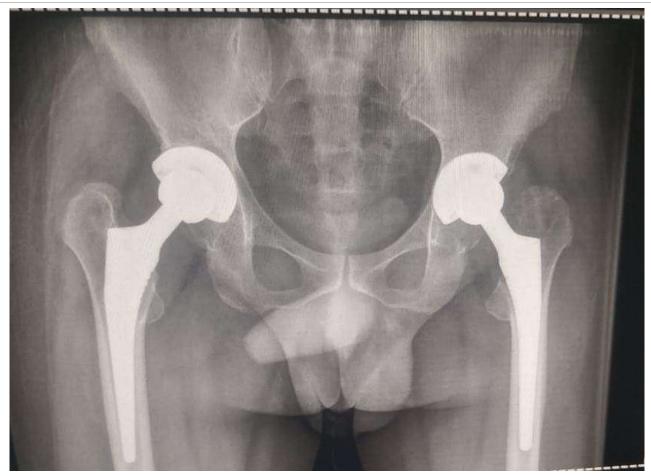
Post-operative X-ray of hip joint showing bilateral THA
